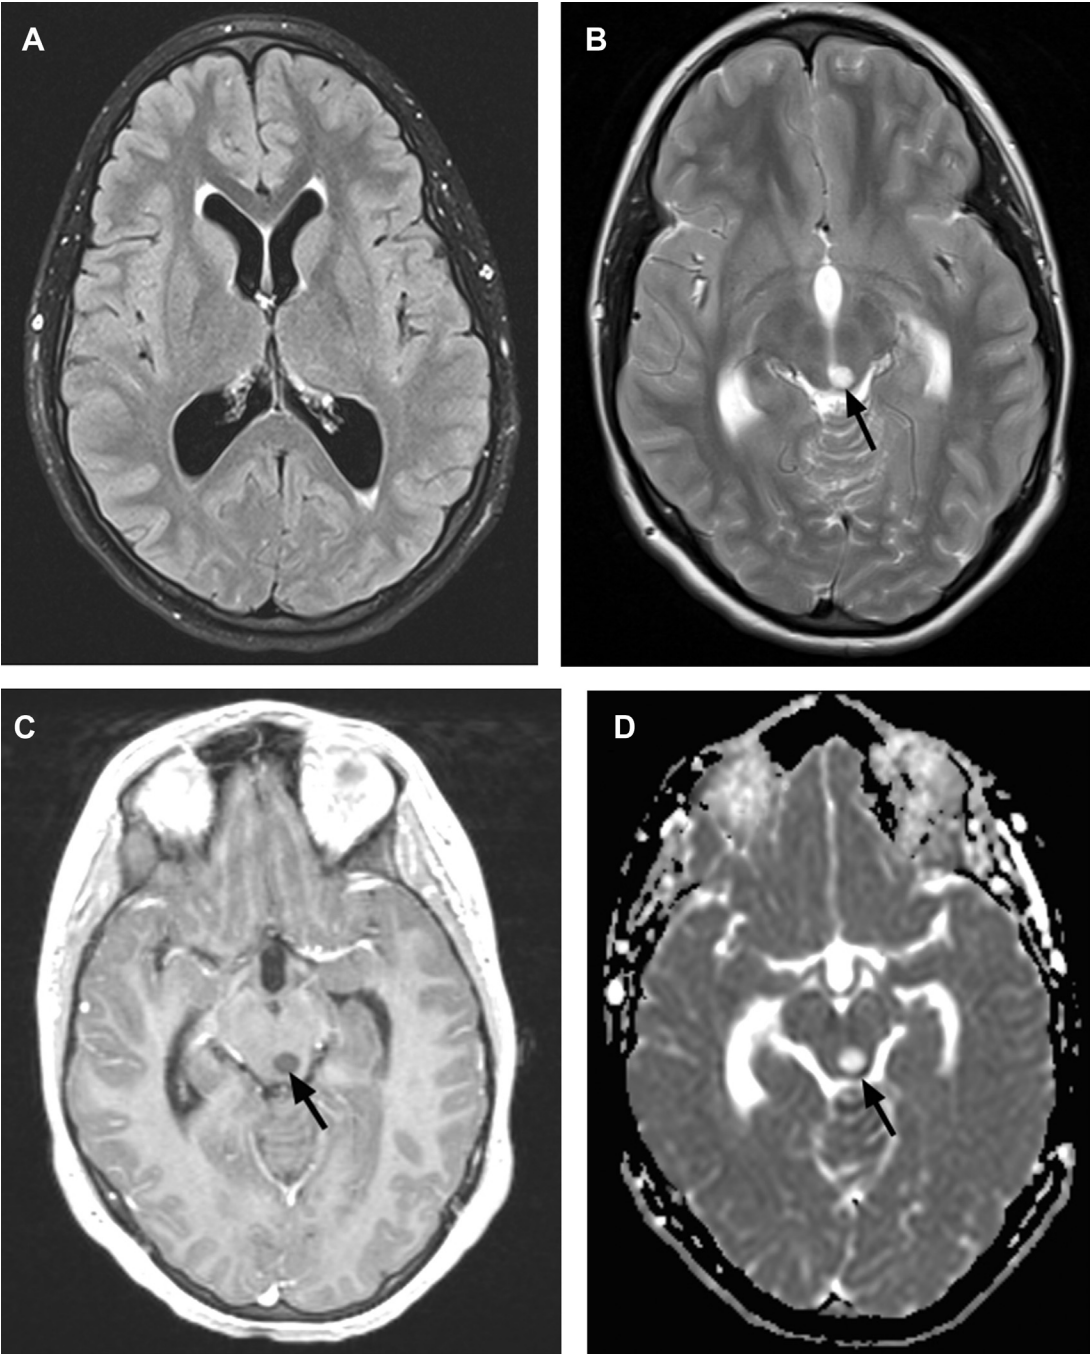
A 12-year-old girl with 2 weeks of headache due to tectal glioma causing obstructive hydrocephalus. (A) Axial FLAIR MR imaging demonstrates mildly dilated lateral ventricles with transependymal edema. Axial T2-weighted (B) and postgadolinium 3D T1-weighted gradient echo images (C) and apparent diffusion coefficient map (D) demonstrate a nonenhancing small, round tectal tumor with T2 prolongation and facilitated diffusion (arrows). The patient underwent endoscopic third ventriculostomy.
